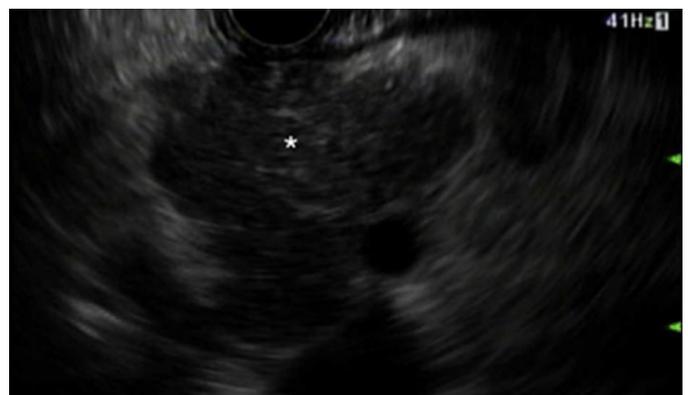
Endoscopic ultrasound demonstrating pancreatic parenchymal changes consistent with inflammation.
